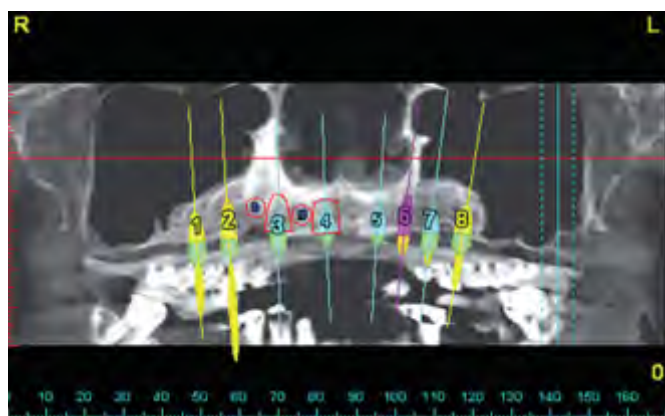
A computer screen shot of the panoramic image of the CBCT scan. Eight implants were planned for this patient. The implants were numbered by the software manufacturer in order of placement (maxillary right posterior quadrant to the maxillary left posterior quadrant, 1 through 8). The anterior teeth were not visible in this particular frontal slice. Implants numbered 1, 2, and 8 were 5-mm-diameter implants; the other implants were 4.1-mm- and 3.25-mm-diameter implants.
